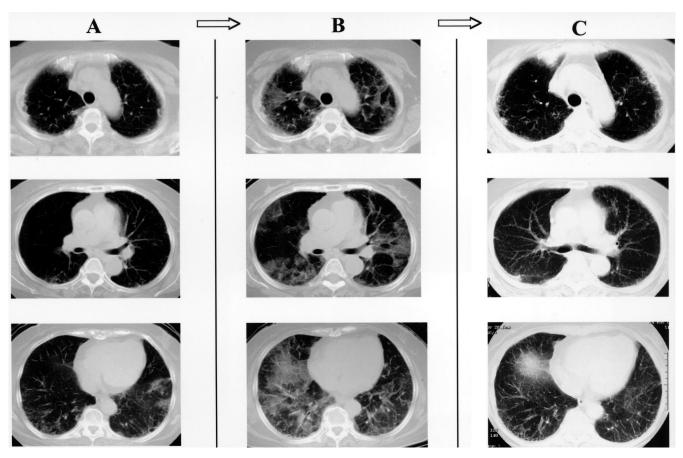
Chest CT findings: A, when LEF was stopped, February 2, 2004; B, on admission, February 18, 2004; C, on discharge March 5, 2004.
